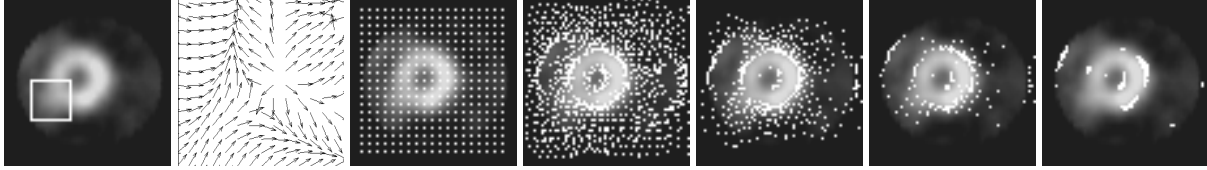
From left: original 64×64 cardiac SPECT image of a LV with a window highlighting a weak edge area, the normalized Lorentz force field within the windowed area, the initialized CPM [4] particles, and iterations of particle movements with the final result on the right.
